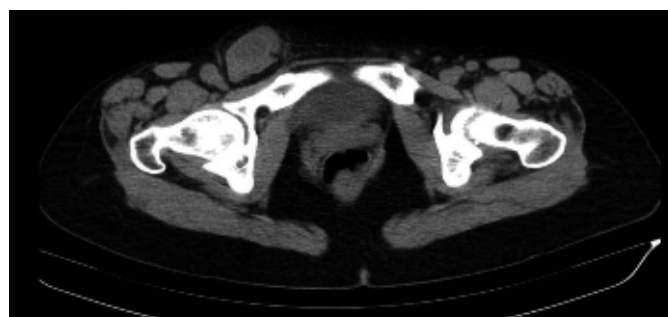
CT-scan demonstrates a "right inguinal hernia containing small bowel with perivisceral fluid in it without signs of small bowel occlusion or perforation": a misleading diagnosis.
